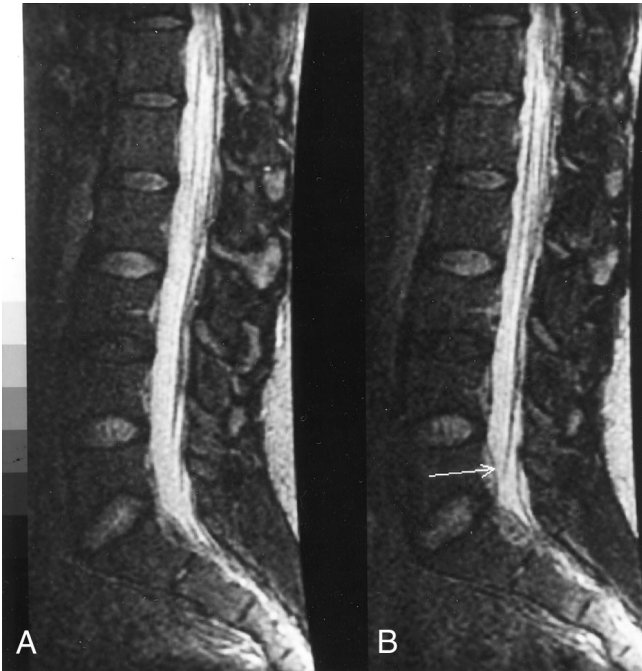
Representative 1-mm sagittal fat-saturated T2-weighted partition images of case 3. A, At rest. B, With abdominal compression and mild hyperventilation. Note the markedly engorged epidural venous plexus at all vertebral levels in B, indicated, for example, at L5 (arrow), deforming the thecal sac and causing decreased lumbar CSF volume.
